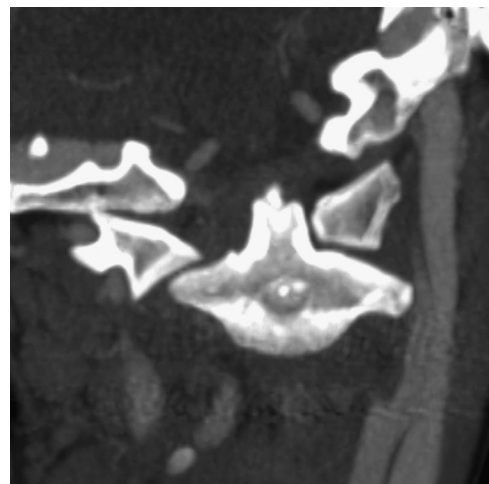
Contrast-enhanced CT to evaluate for abscess in a 5-year-old boy with neck inflammation demonstrates an asymmetric LAI: 8.4 mm on the right and 0.7 mm on the left. The difference of 7.7 mm is abnormal based on our results. This helps to confirm pathologic torticollis.
